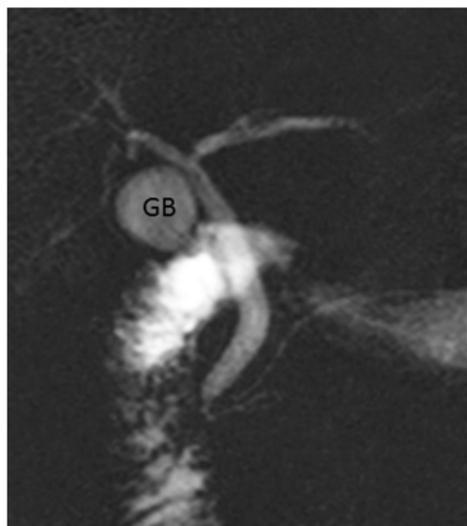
Magnetic resonance image (MRCP) of remnant gallbladder (GB).
